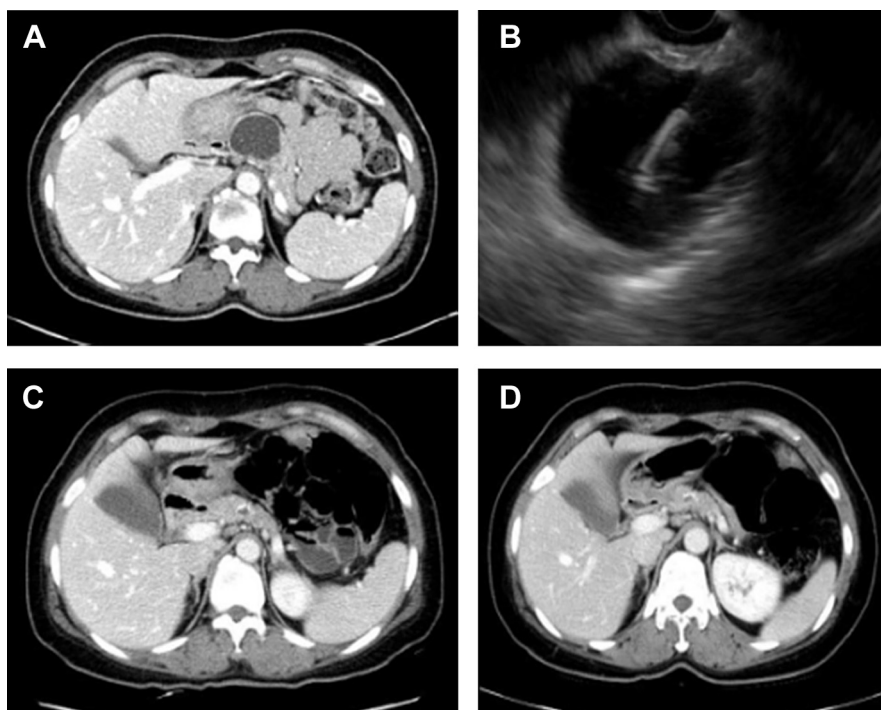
Complete remission of mucinous cystic neoplasm after endoscopic ultrasound guided ablation. (A) Computed tomography showing a solitary 3.6 cm cystic lesion at the body of the pancreas. (B) Endoscopic ultrasound revealing a uniloculated cyst without communication to the pancreatic duct. Clinically, it is consistent with mucinous cystic neoplasm. Ablation was performed with ethanol lavage followed by paclitaxel injection. (C) Follow-up computed tomography 1 year later showing markedly shrinkage of the cystic lesion (1.2 cm) with peripheral calcification. (D) Follow-up computed tomography 3 years later showing further reduction in the size of the residual cyst, measuring < 1 cm. New lesions are not evident.
